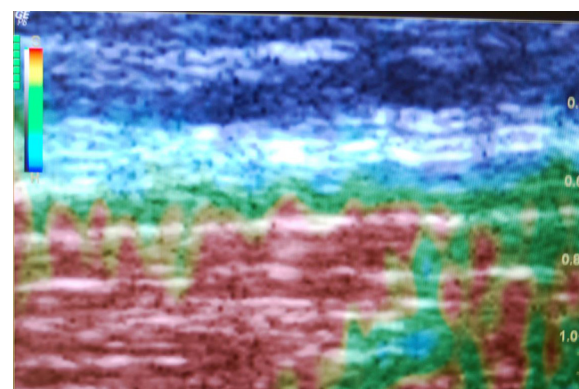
Ultrasound image of the center of coordination RE-TA. Left side image before Fascial Manipulation® and right side after the treatment. DF = deep fascia.
